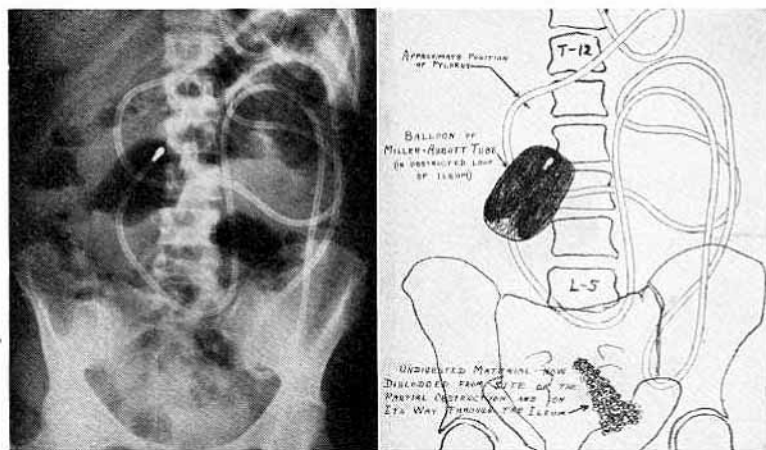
Case I. Ventral projection with patient sitting, after passage of the Miller-Abbott tube. The balloon was left uninflated until fluoroscopy showed the advancing head of the tube in the descending portion of the duodenum. Progress to that point was slow and required about one hour, with a certain amount of manipulation under fluoroscopic guidance, to hasten the passage of the pylorus. After distention of the balloon, progress was very rapid. The principal lumen of the Miller-Abbott tube was kept connected to Wangenstein suction apparatus. When the measuring marks on the Miller-Abbott tube showed a distance of 3 feet beyond the pylorus, the patient became perfectly comfortable. By this time all gas collections in the small intestine had disappeared except the collection of air in the distended balloon of the Miller-Abbott tube. About 2 pints of corrosive, odorous, brownish liquid had been recovered through the principal lumen of the tube. Note the shadow of the obstructive material, apparently dislodged from the obstructed loop of the ileum and shown by this roentgenogram as it was on its way through the terminal ileum.
